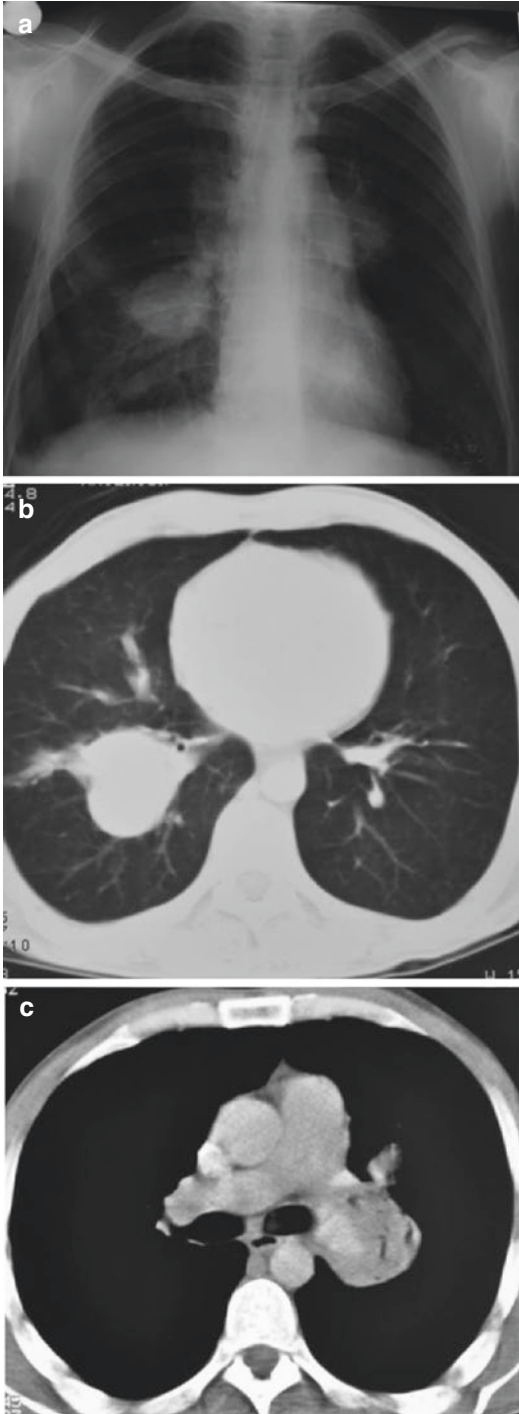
Pulmonary artery aneurysms: (a) chest plain radiography and (b, c) computed tomography (CT) scans of a young male patient with Behçet's syndrome: multiple aneurysms completely thrombosed can be observed. Aneurysms are located on the right descendant artery (5 cm), distal portion of the left main artery (5 cm), and on the left descendant artery (1.5 cm) (Figure courtesy of Professor Emire Seyahi, MD)
